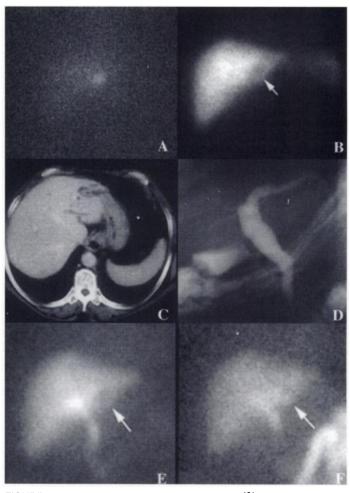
Hepatic view of therapeutic whole-body ¹³¹I scan (A), liver scan (B), abdominal CT (C), ERCP (D) and radionuclide cholangiography at 5 min (E) and 2 hr (F). There was a focal retention of radioactivity at the left lobe of the liver on whole-body ¹³¹I scan corresponding to a cold area seen on liver scan (white arrow). Abdominal CT and ERCP showed prominent left IHD dilatation. Radionuclide cholangiography showed a cold area at the left lobe of the liver at 5 min (white arrow) and then the cold area was filled with radioactivity at 2 hr (white arrow).
